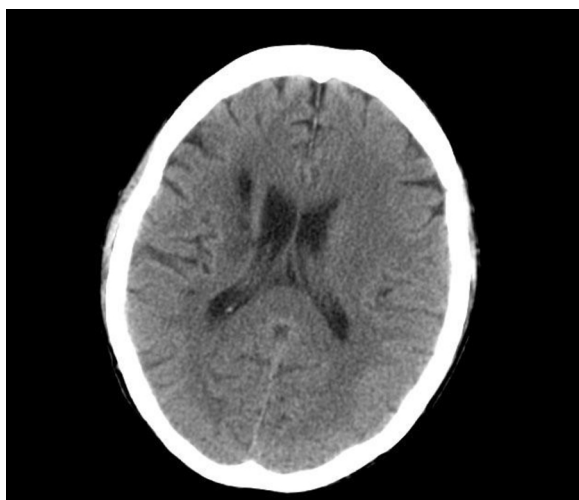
Head computed tomography revealed cerebral infarction at onset.
